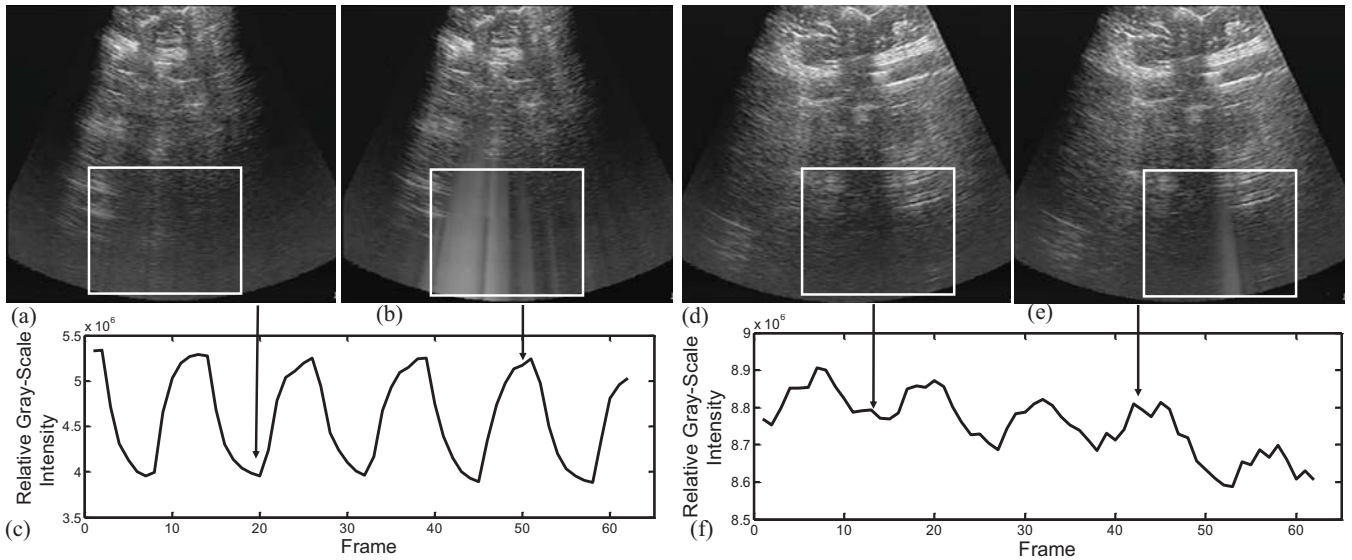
Measured results showing sensor data received by the ultrasound scanner for two different levels of power dissipation at the sensor: (a) B-mode image during the OFF state of the data modulation cycle (1mW power dissipation); (b) B-mode image during the ON state of the data modulation cycle (1mW power dissipation); (c) Demodulated sensor data obtained after parsing the grey-scale ultrasound video (1mW power dissipation); (d)(e)(f) results obtained when the power dissipation at the sensor is 10μW;
